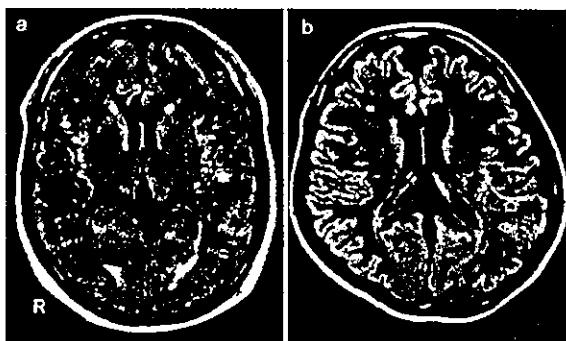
A FLAIR image in patient 2 (a). The image was obtained 1 hour after symptoms onset. A linear high intensity is demonstrated (solid arrow). A FLAIR image in patient 3 (b). The image was obtained 3 hours after stroke onset. A linear high intensity corresponding to a branch of MCA is visualised (open arrow).
